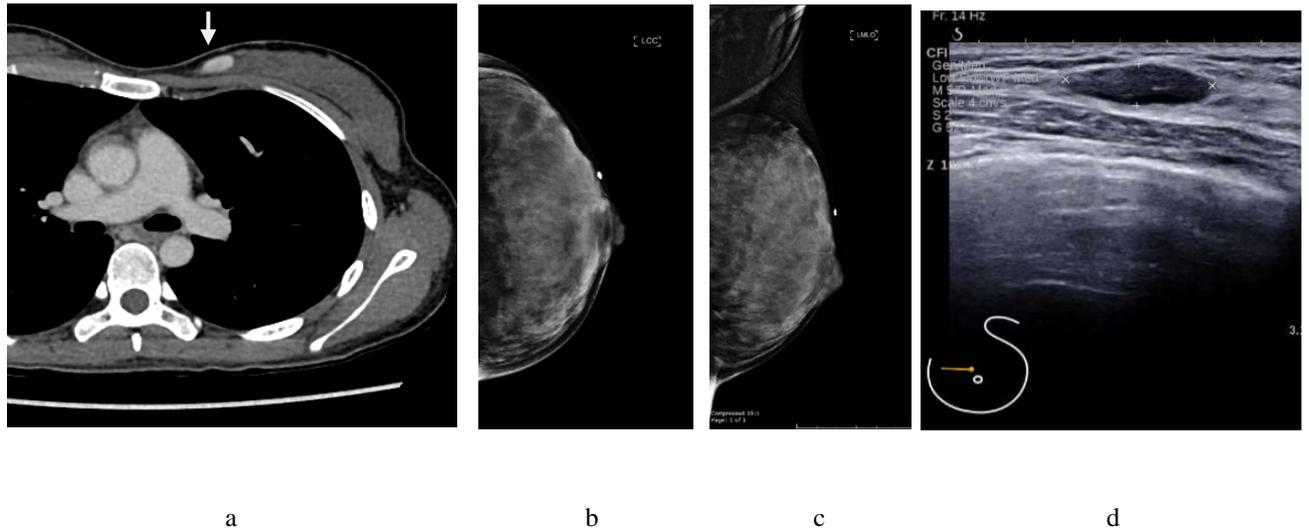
(a) Axial contrast enhanced CT showed circumscribed enhancing mass on the left breast (arrow). (b) and (c) Mammography CC and MLO views with skin marker showed extremely dense fibroglandular breast, no mass visualized.(d) Additional ultrasound demonstrated a well-defined hypoechoic mass at left upper inner quadrant which corresponding to the mass on CT scan (BI-RADS 4 lesion).
